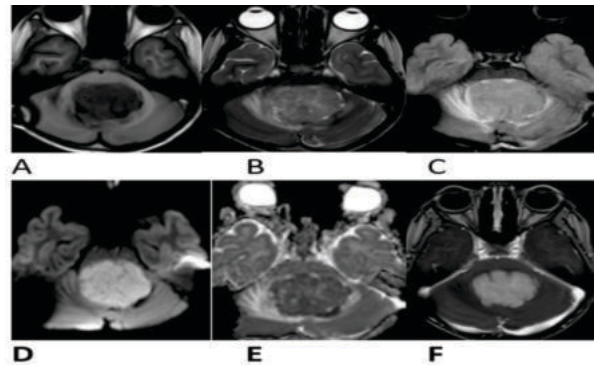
A) Axial T1 weighted MR images showing well circumscribed hypointense intraaxial mass lesion with perilesional oedema noted arising from 4th ventricle B) lesion is heterogeneously hyperintense on T2 weighted images C) on FLAIR images there is no suppression D) on post contrast T1 weighted images there is intense heterogenous post contrast enhancement E) and F) DWI and ADC maps showing diffusion restriction more than brain parenchyma with ADC values 0.6×10^{-3}
